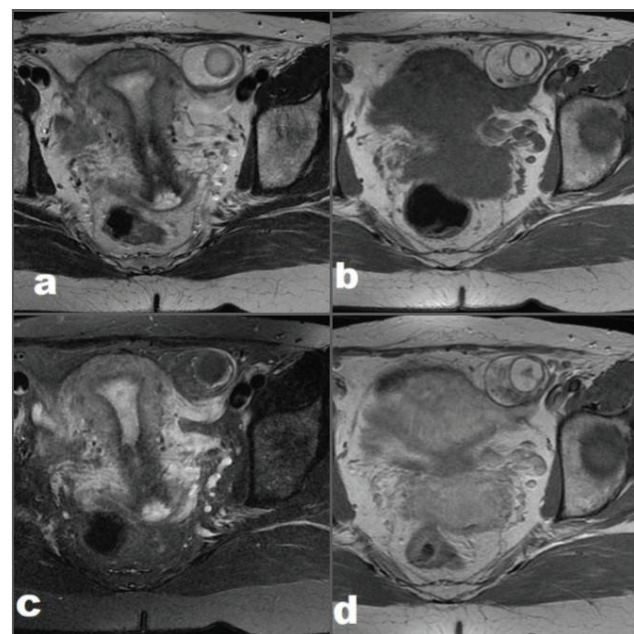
MRI tra of dermoid cyst: a. T2w, b. T1w, c. T1fs, d. CE T1w
